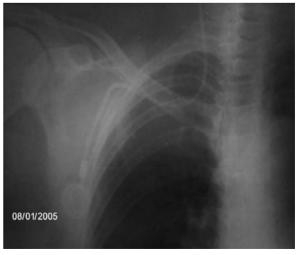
Chest X-ray with mal-directed subclavian catheter to the epsi-lateral internal jugular vein.
